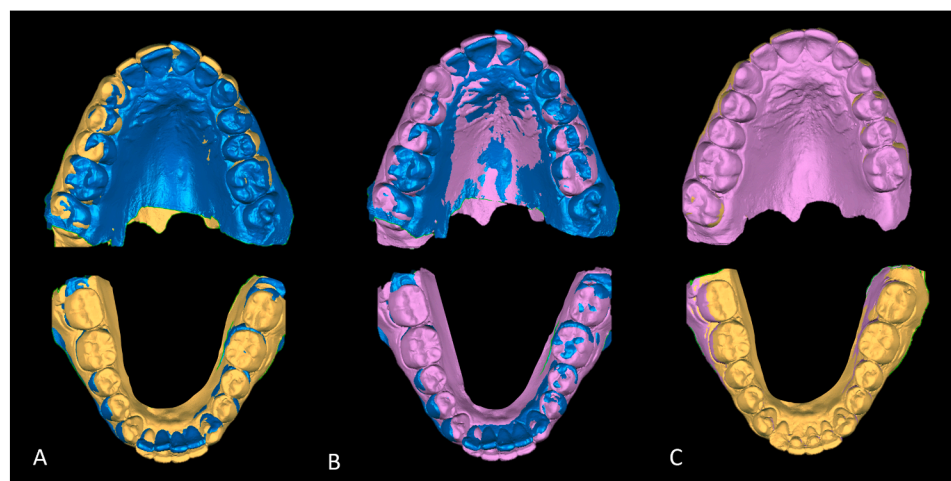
Comparison of superimposition methods using a common initial reference: A, Final models (UTomoT1 and LTomoT1) registered by CBCT-based superimposition; B, Final models (UModelT1 and LModelT1) registered using the palatal rugae and the occlusion; C, Differences between methods relative to T0.
